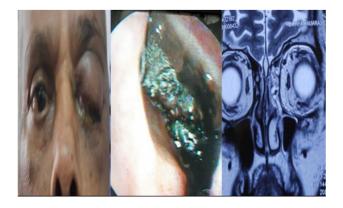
Patient with proptosis (a) proptosis left eye, (b) black middle turbinate, and (c) MRI sinus with orbit.
